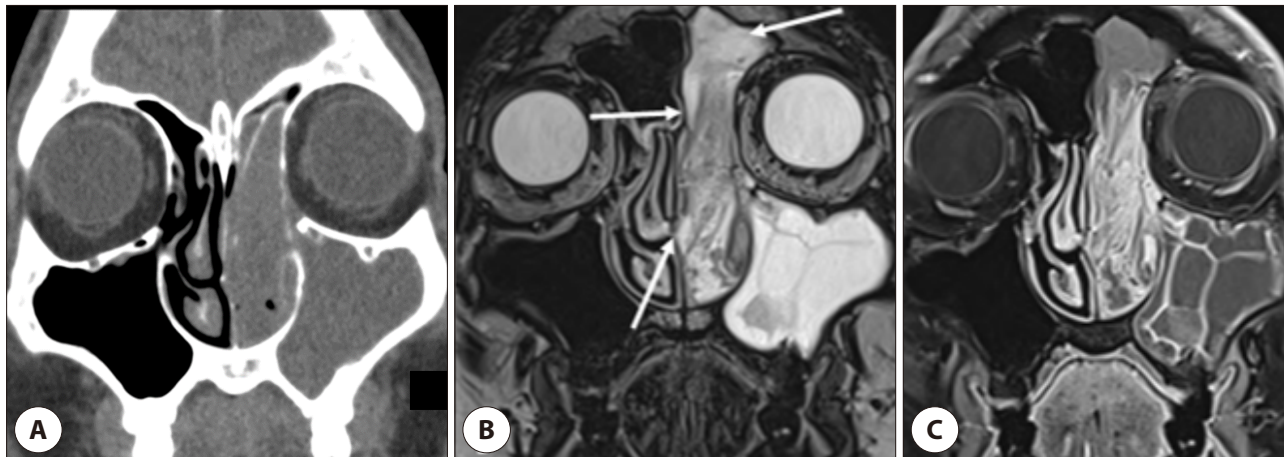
A 57-year-old male with inverted papilloma originating from the lateral wall of the ethmoid sinus. On CT (A), sclerosis suggesting origin is not evident. T2WI (B) reveals peritumoral hyperintense layers at the inferior, medial and superior portions (arrows) of the mass but not at the lateral wall. Gd-T1WI (C) shows contrast enhancement in both the mass and peritumoral edematous mucosa, obscuring the mass origin. T2WI: T2-weighted image, Gd-T1WI: Gd-enhanced T1-weighted images.
